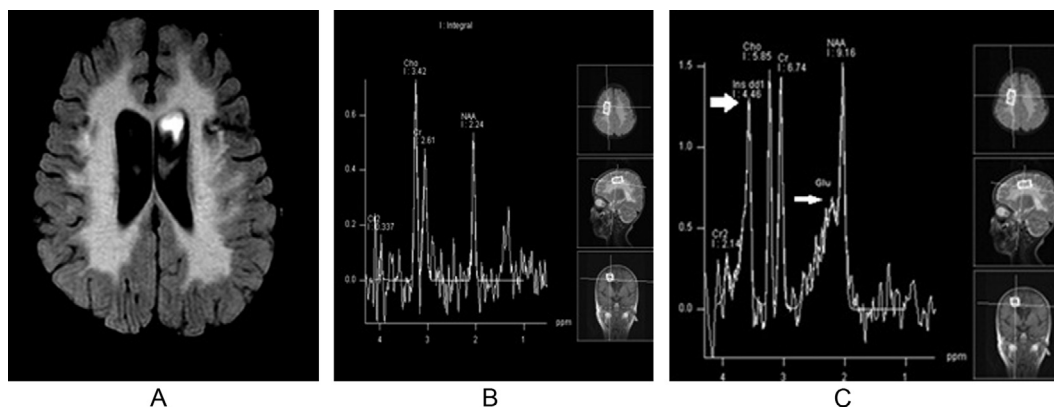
Child male 3 years old with metachromatic leukodystrophy (A): axial T2 FLAIR images of the brain revealed bilateral symmetrical confluent areas of signal change in periventricular white matter with characteristic tigroid appearance, (B & C) MRS at long and short TR shows high myoinositol (mI) level (thick white arrow) and Glx (thin white arrow) (C), raised lipid/lactate with high MI/Cr level, lac/Cr 0.32.
